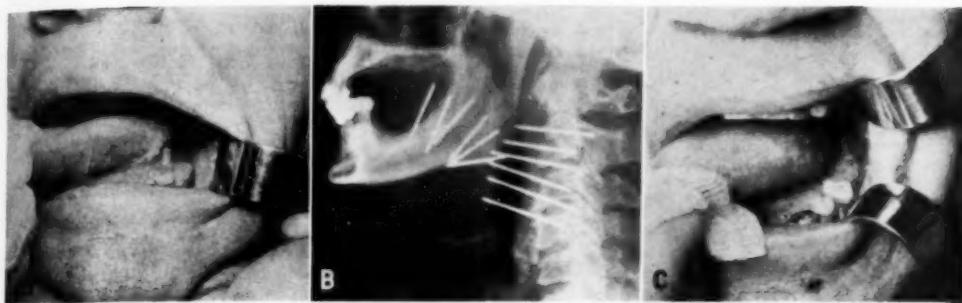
A. Photograph showing anterior edge of a deep-seated carcinoma of the posterolateral tongue. B. Roentgenogram showing the needle pattern in the tongue and also beneath a metastatic node in the upper left neck. C. Complete primary healing two months later.
